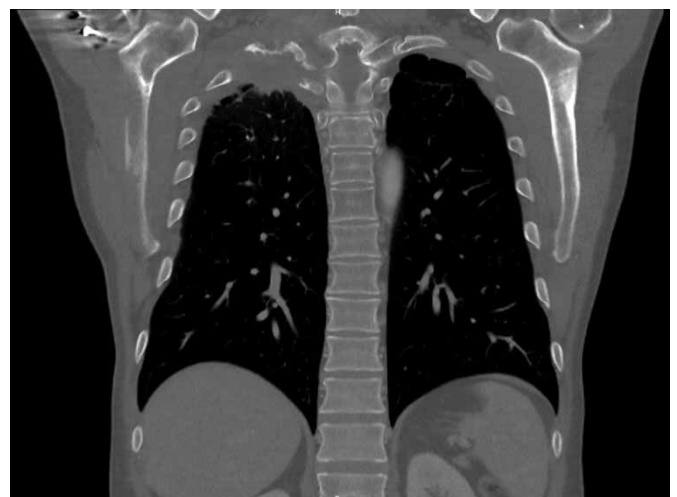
Chest computed tomography scan, coronal reconstruction (bone window contrast): right mass invading apex and eroding the posterior first and second ribs and the right lateral part of the second dorsal vertebra.
